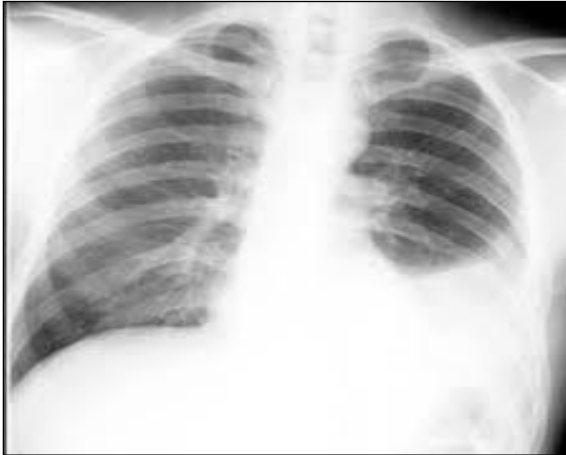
Chest radiograph P/A view left sided pleural effusion.
